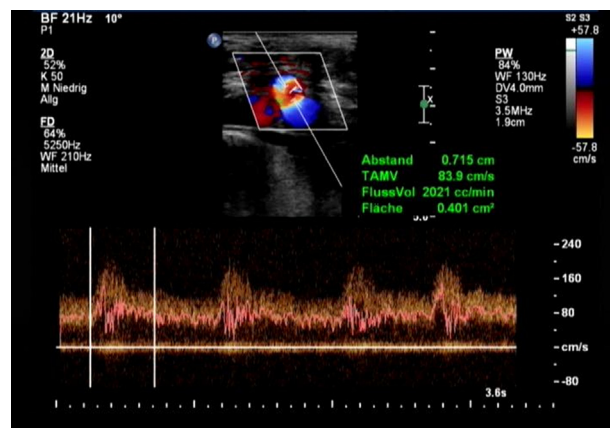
Doppler/duplex sonography with the pulsed-wave doppler window within the arteriovenous fistula demonstrates a calculated flow volume of 2021 cc/min.
